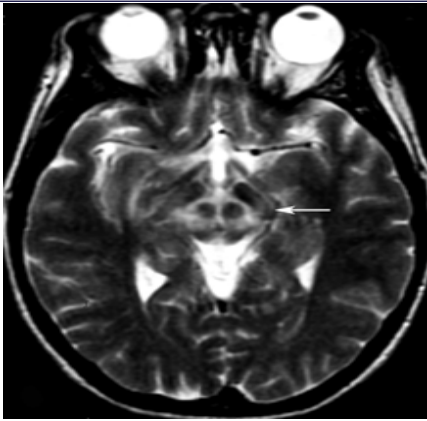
MRI Showing Face Of Gaint Panda
